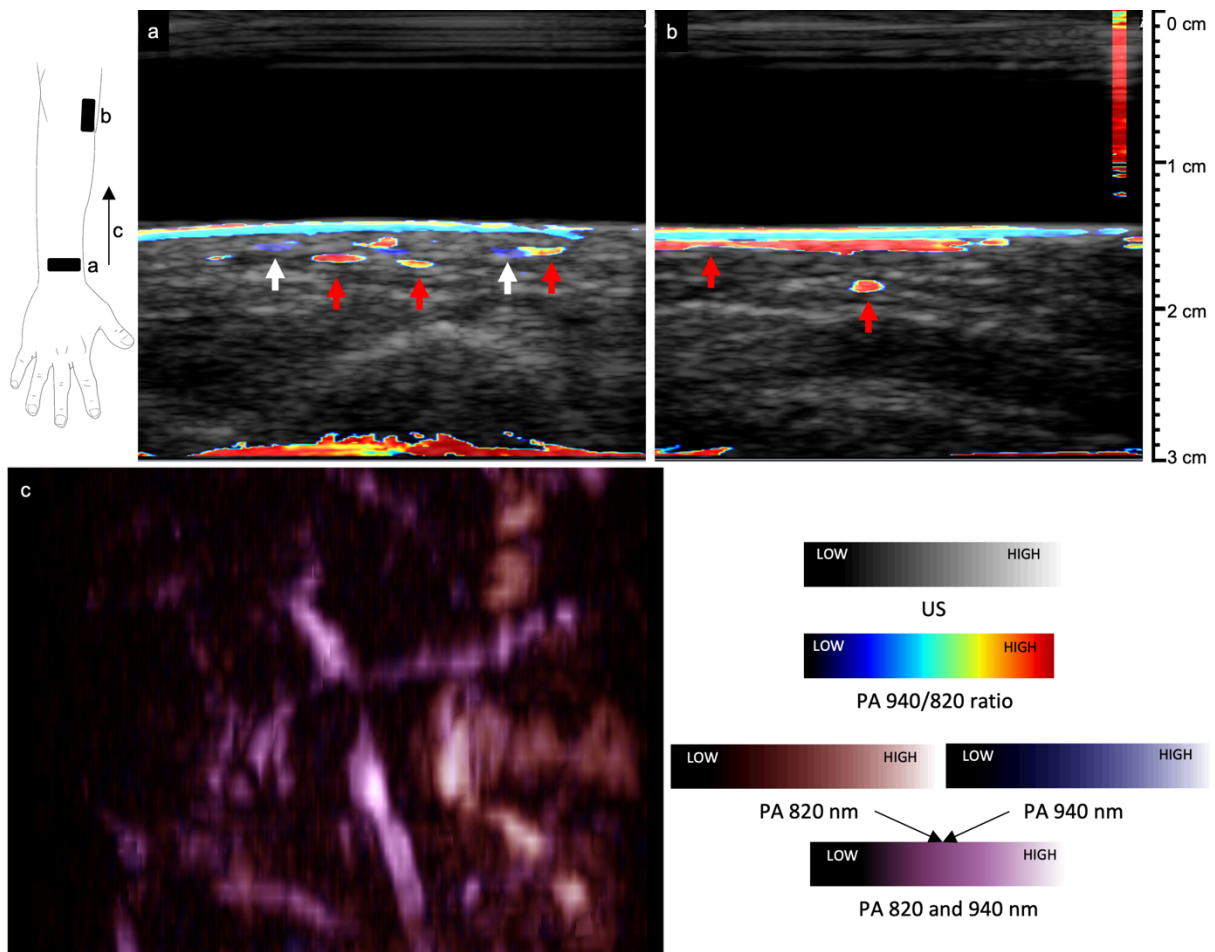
Ultrasound and 940/820 nm ratio photoacoustic (PA) images of a healthy arm (patient 2). White arrows indicate lymphatic vessels and red arrows indicate blood vessels. (a) Axial PA image slice of the dorsal forearm. Multiple lymphatic vessels (dark blue) and veins (dark red) are visible. (b) Parallel PA image slice of the elbow fold. A vein (dark red) is clearly visible along the length of the image. (c) Maximum intensity projection with skin melanin surface suppression of the dorsal forearm of healthy lymphatic vessels and blood vessels. 820 nm signal is displayed in red and in blue for 940 nm. Signal origination from both wavelengths is displayed in purple (mix of red and blue).
